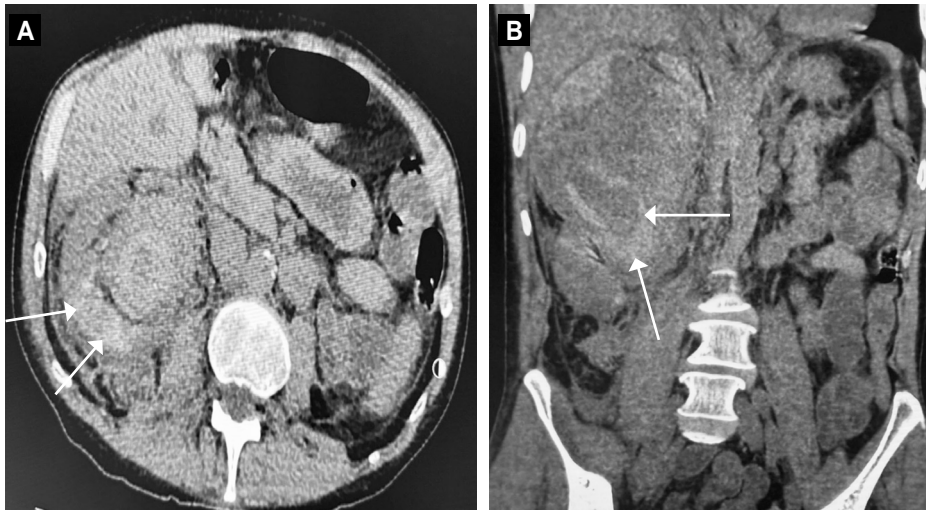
Axial (A) and coronal (B) unenhanced computed tomography slices of the abdomen show hyperdense foci within the mass (white arrows), suggestive of ongoing haemorrhage
